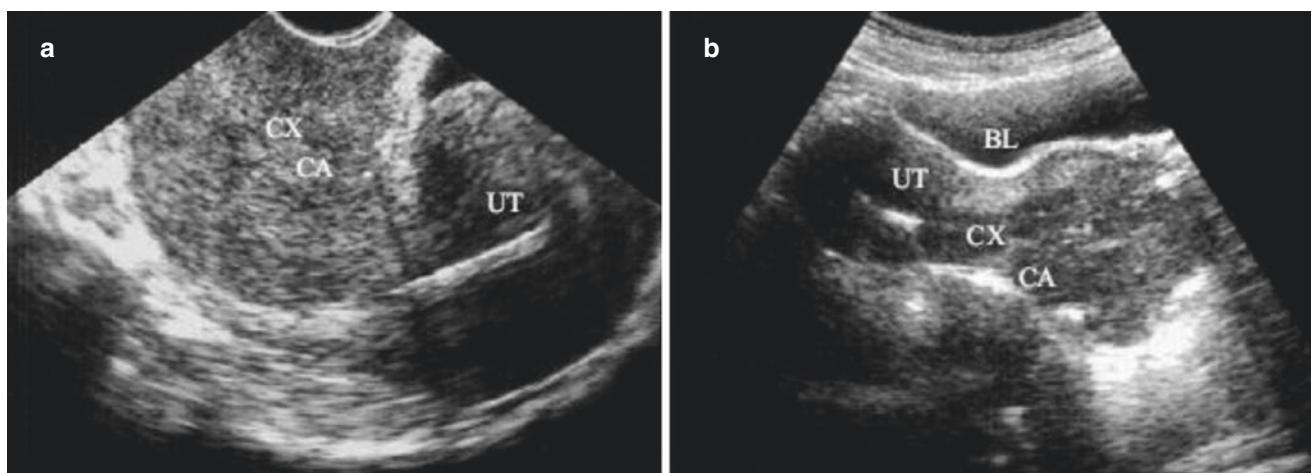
Cervical cancer (I). (a) Sagittal view of TVS shows a larger cervical diameter compared with the uterine anteroposterior dimension, and the cervix is hypoechoic. (b) Transabdominal ultrasonography
